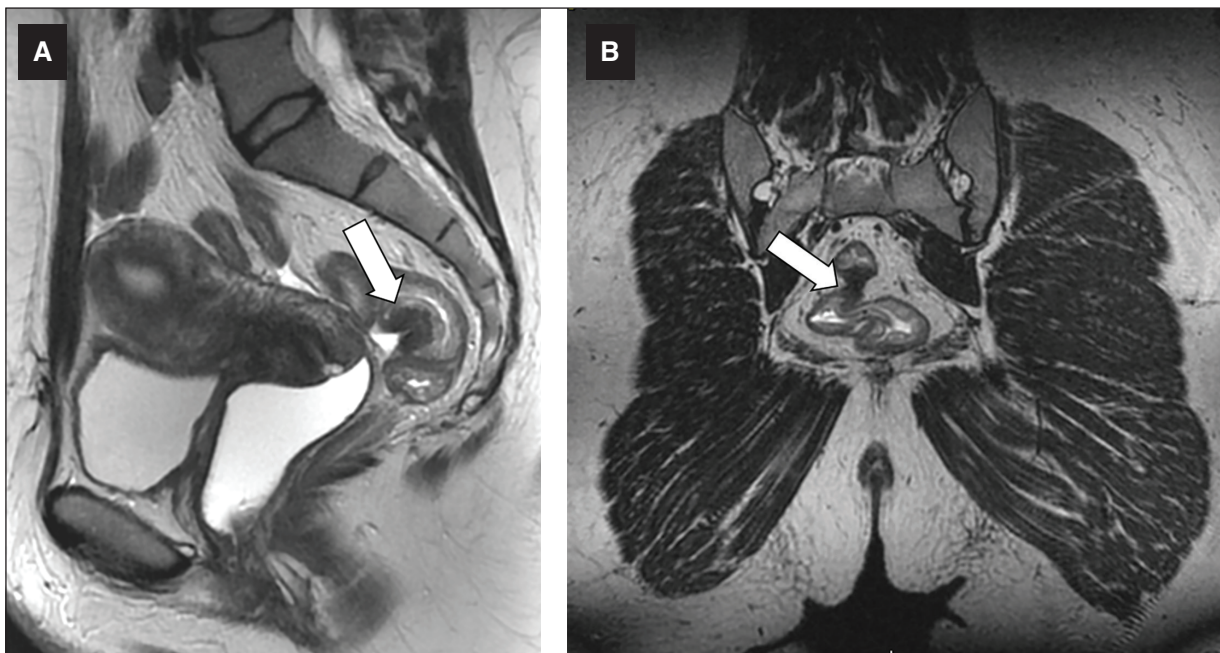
Rectal endometriosis in a 37-year-old woman with pelvic pain and dyschesia. A: sagittal. B: coronal. T2-weighted MRI demonstrating a nodule with low signal intensity attached to the anterior rectal wall and deeply infiltrating the muscularis propria from outside-in (arrows). MRI: magnetic resonance imaging.
